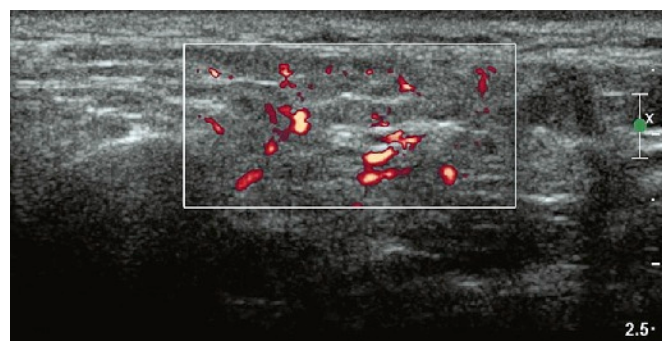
Abnormal vascularization of a parotid gland is seen with power Doppler.
